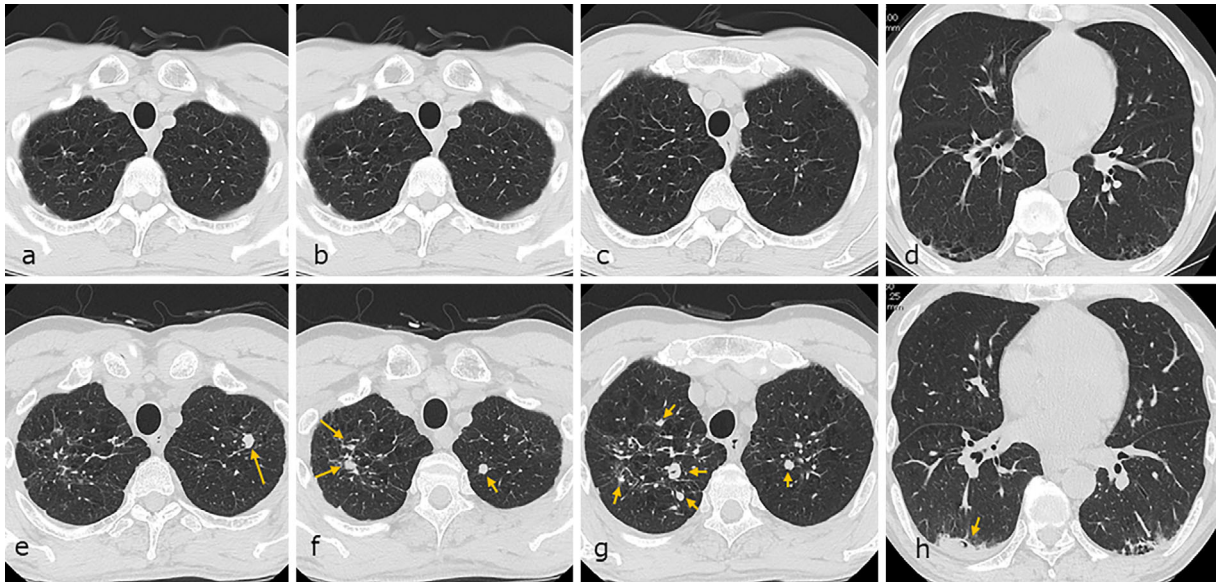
The computed tomography findings at two years before presentation (a-d), and at presentation (e-h). Multiple well-defined nodules of soft tissue attenuation were seen (e-h). A nodule in the left upper lobe (f) was resected thoracoscopically five months after presentation.
